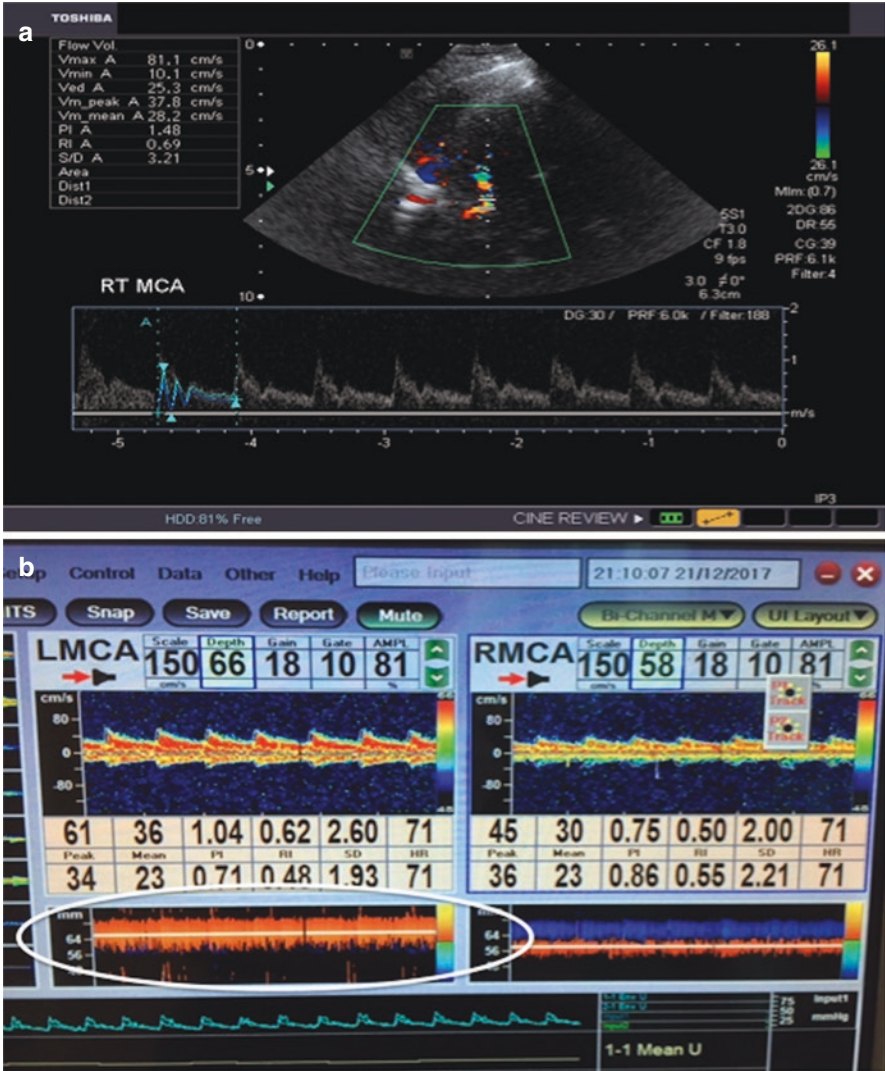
CBFV waveform and M-Mode via TCD of the MCA. CBFV cerebral blood flow velocity, MCA middle cerebral artery, TCD transcranial Doppler. Panel (a): Unilateral insonation of the right MCA. Panel (b): Bilateral simultaneous insonation of the MCA, with the white circle highlighting the M-mode display
